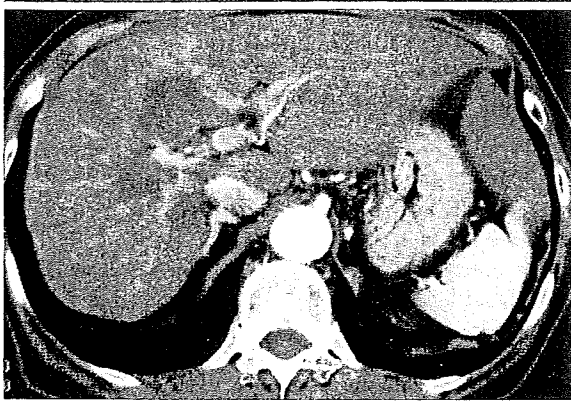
Intravenous contrast-enhanced CT scan showing lipiodol accumulation in the tumor and decreased tumor size 1 week after the third chemoembolization.
